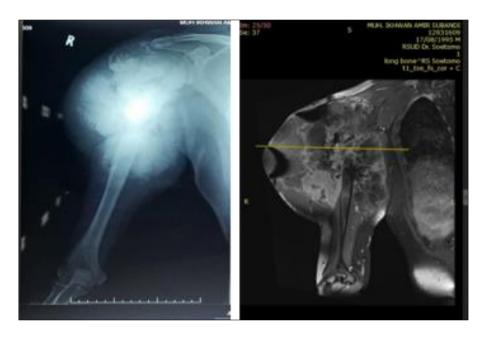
(A) Pre-operative x-ray; (B) Pre-operative MRI
